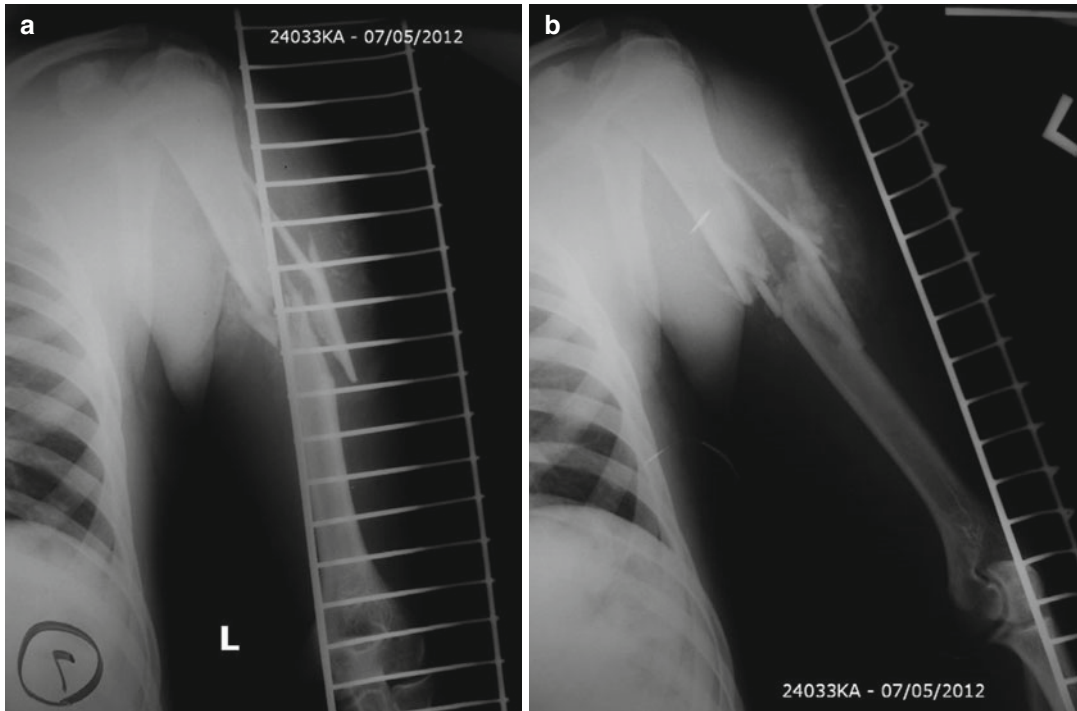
Preoperative (a) AP and (b) lateral X-rays of patient discussed in Case 1
